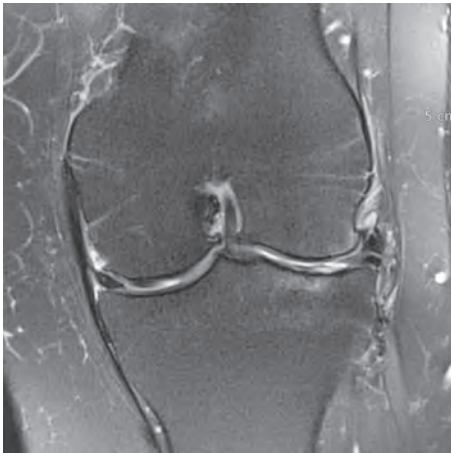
MRI showing ACL fibres engulfed in osteophytes of the inter-condylar notch (X-Ray on figure 8).
